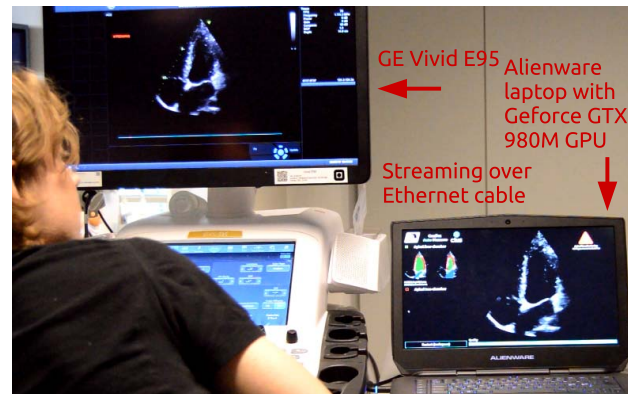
Hardware setup used for real-life testing. Ultrasound images are streamed in real-time from a GE Vivid E95 scanner to a laptop with a GPU which runs the proposed method.
